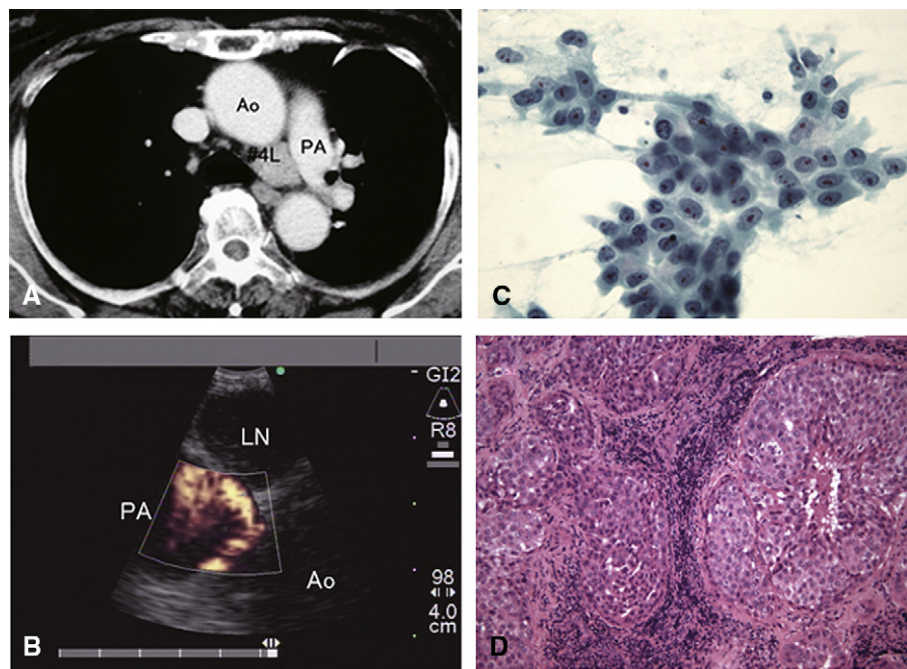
A, CT scan demonstrates enlargement of lymph node 4L in 68-year-old patient with lung cancer of the left lower lobe. B, EBUS images with the Doppler mode show 4L (LN) between the aorta and the pulmonary artery. Cytologic and pathologic results demonstrate adenocarcinoma (C, D). AO, Aorta; PA, pulmonary artery; LN, lymph node.
